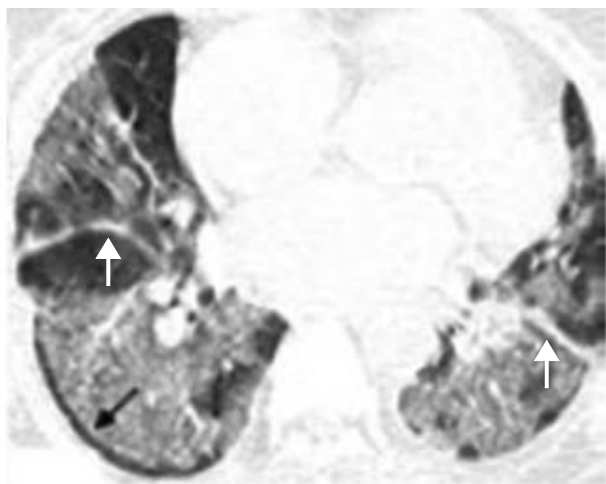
Axial chest CT image of a 78 year old female who were followed in international care unit for serologically confirmed Covid-19 pneumonia show bilateral extensive panlobar ground glass opacities (GGO) with the appearance of "white lung". Note the presence of thin subpleural sparing associated with GGO in the right lower lobe (black arrow).
